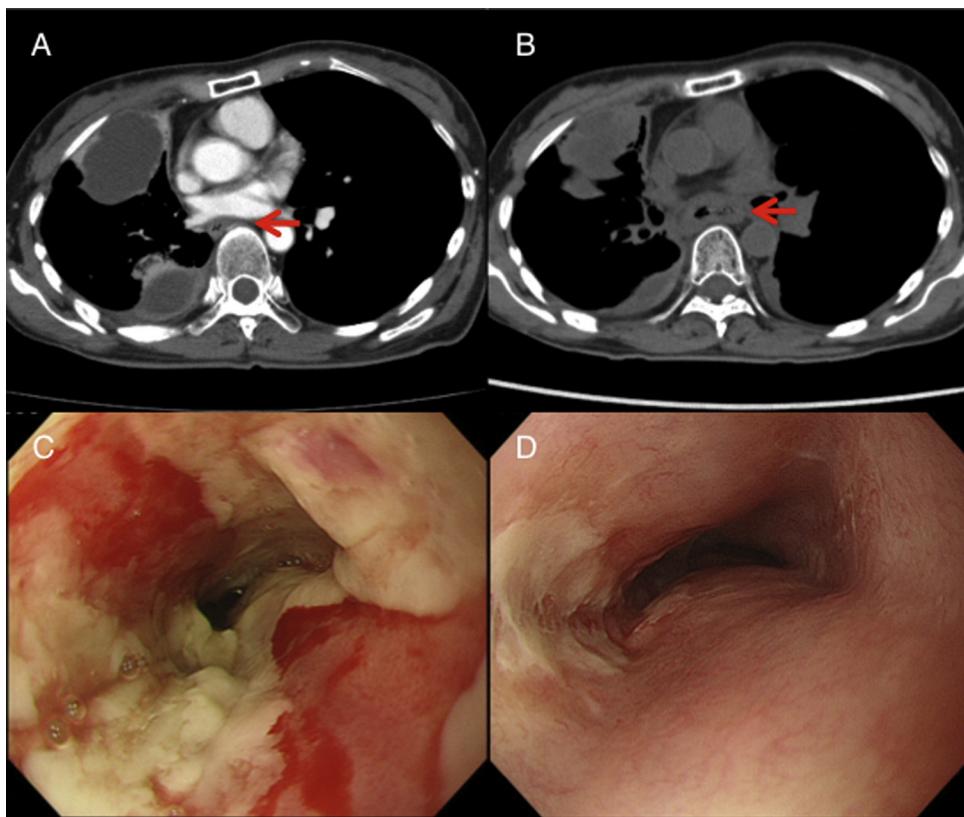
CT and endoscopic imaging of esophageal ulceration. A CT scan showed no esophageal abnormality before crizotinib treatment (A) but severe circumferential esophageal wall thickening after 4 days of such treatment (B). Arrows indicate the esophagus. Endoscopy revealed circumferential ulcer of the esophagus after 4 days of crizotinib treatment (C) and disappearance of the ulcer at 10 days after cessation of the treatment (D).
